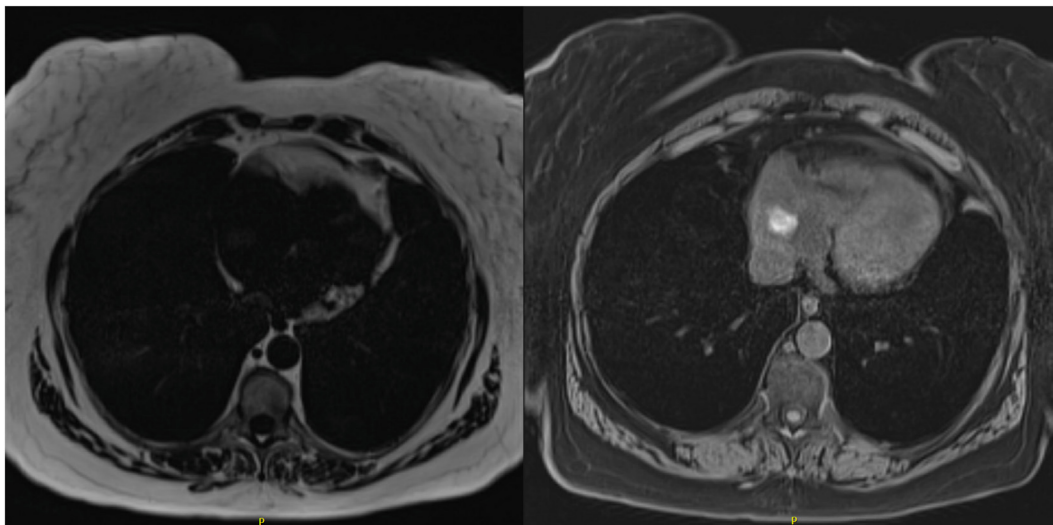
Cardiovascular magnetic resonance, T1-weighted sequences (axial view) showing the mass as isointense with extensive areas of hemorrhage/breakdown within the mass, accounting for focal areas of hyperintensity.
